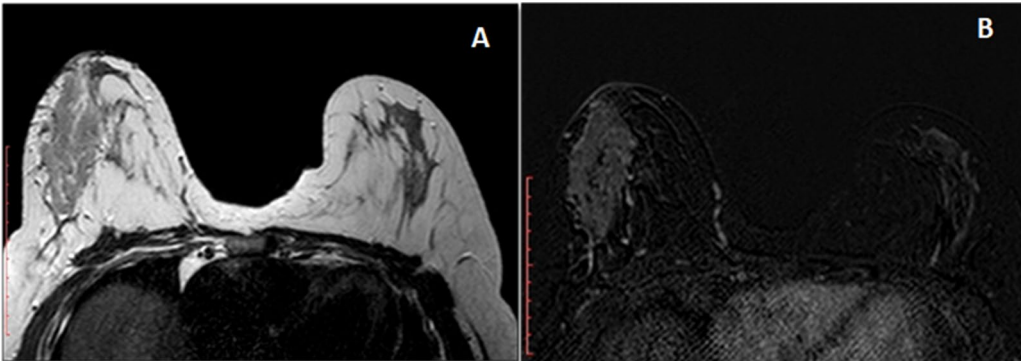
A 38-year-old female presenting with right breast lump, skin redness, and tenderness. She was resistant to proper medical treatment. Pathology revealed benign pathology; non-specific granulomatous mastitis. A Axial T2-weighted MRI image shows segmental area of intermediate to bright signal intensity (true negative). B Axial post-contrast dynamic series shows segmental non-mass enhancement (false positive)
